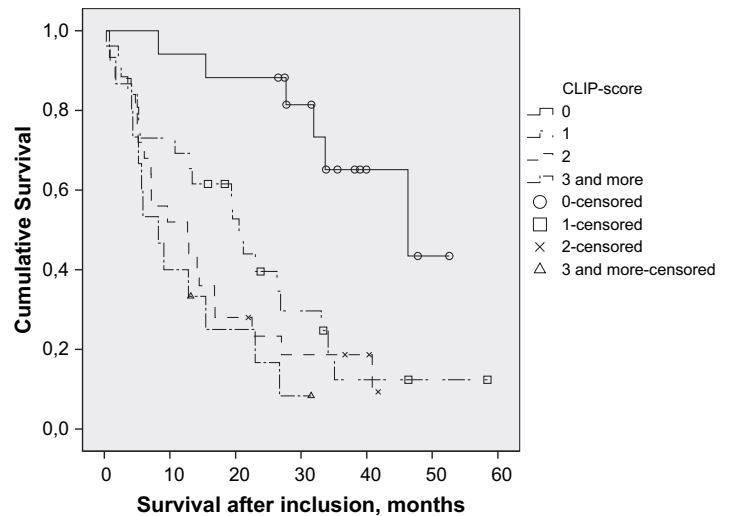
Overall survival in study patients after computed tomography-guided brachytherapy.
